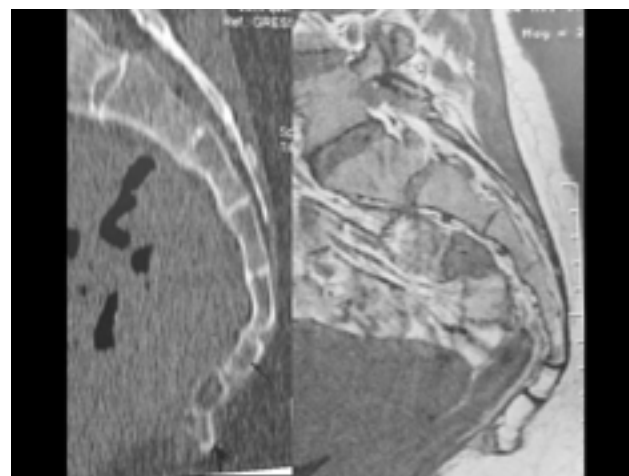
CT-MRI comparison. The spicule is more visible on CT (sagittal 2D reconstruction, left) mainly due to the use of thinner sections. On MRI, right, the image does not reflect reality.
